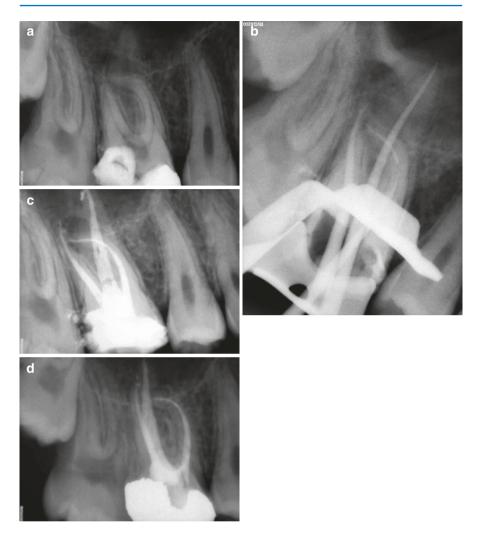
(a) Preoperative radiograph. (b) Master cone radiograph. The fragment of the NiTi instrument can be seen at the apical third of the mesiobuccal canal. (c) Instrumentation and obturation up to the fragment. The fragment can hardly be identified at the immediate post-obturation radiograph. (d) Six-month recall radiograph (Courtesy of Dr. Ch. Beltes)
